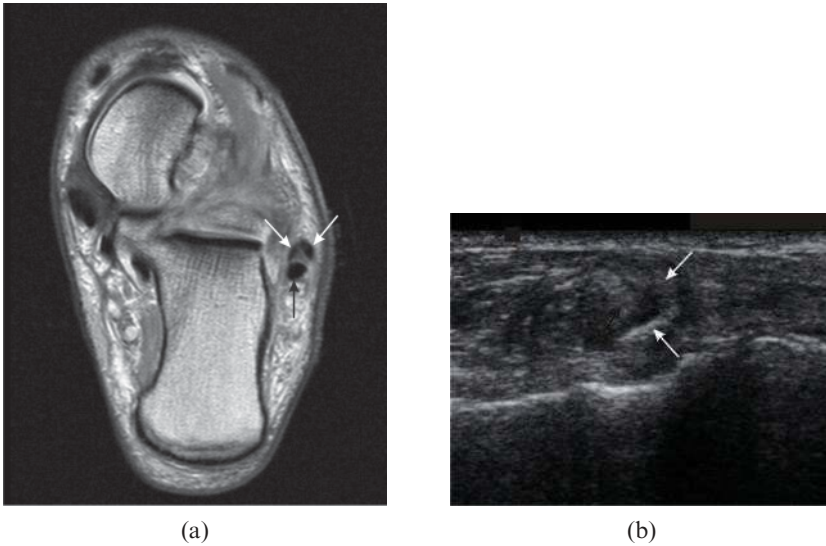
Peroneus brevis split. (a) Axial proton density-weighted MRI. (b) Ultrasound. The split components of the tendon of peroneus brevis (white arrows in both parts) extend around the peroneus longus tendon [black arrow in part (a)].
